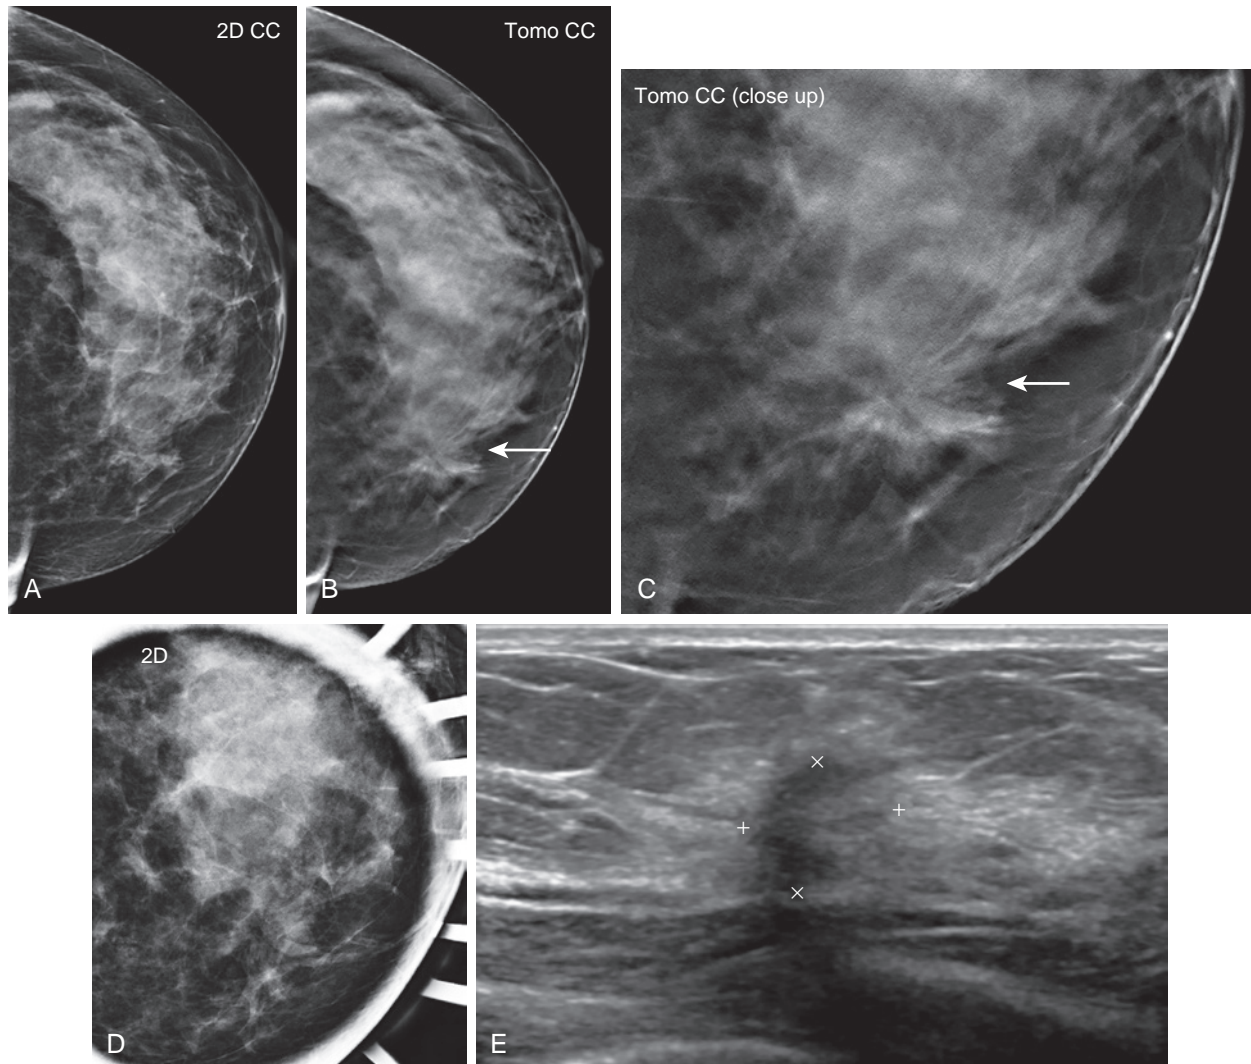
Radial scar with DCIS. A 53-year-old patient presented for screening evaluation. An area of architectural distortion was identified in the left breast. The area was seen on the full-field digital mammography craniocaudal (CC) view (A), but best demonstrated (*arrows*) on the CC tomosynthesis view (B and C). (D) On the 2D spot compression CC view, the area of architectural distortion was less apparent. (E) Breast ultrasound identified an irregular hypoechoic mass. Ultrasound-guided core biopsy was performed, resulting in a diagnosis of radial scar. The patient was recommended to undergo surgical excision, at which time associated ductal carcinoma in situ was diagnosed.
